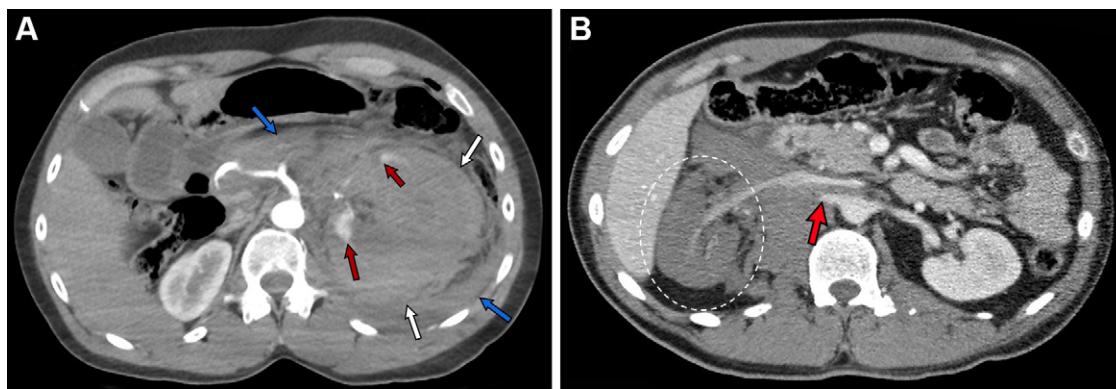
Grade V renal injuries according to the revised 2018 AAST-OIS. (A) Axial contrast-enhanced CT image in a 55-year-old man after a front-end motor vehicle collision at 45 mph shows a shattered left kidney with two small fragments (red arrows) but loss of identifiable renal parenchymal anatomy, and bleeding extending from the Gerota fascia (white arrows) into the peritoneum and retroperitoneum (blue arrows). The patient underwent exploratory laparotomy and left nephrectomy. (B) Axial contrast-enhanced CT image in a 34-year-old man after being crushed between two vehicles shows avulsion of the right renal hilum, right renal artery laceration (arrow), extensive retroperitoneum, and a devascularized right kidney (white oval). Additionally, he suffered a right 10th rib fracture and injuries to the duodenum and transverse mesocolon. The patient underwent right nephrectomy, and avulsion of the hilum and renal artery transection were confirmed during surgery. Absence of exuberant active contrast material extravasation was related to vasospasm and compression by the hematoma. According to the revised 2018 AAST-OIS, all main renal vascular injuries, excluding thrombosis, are reserved for grade V injuries.
